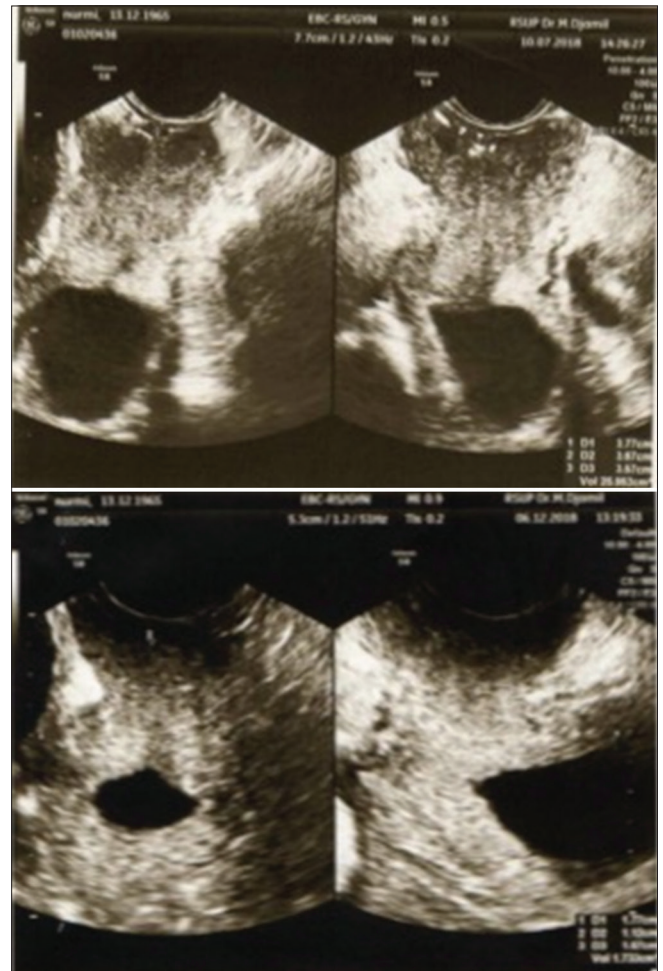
Ultrasound examination before and after neoadjuvant chemotherapy
